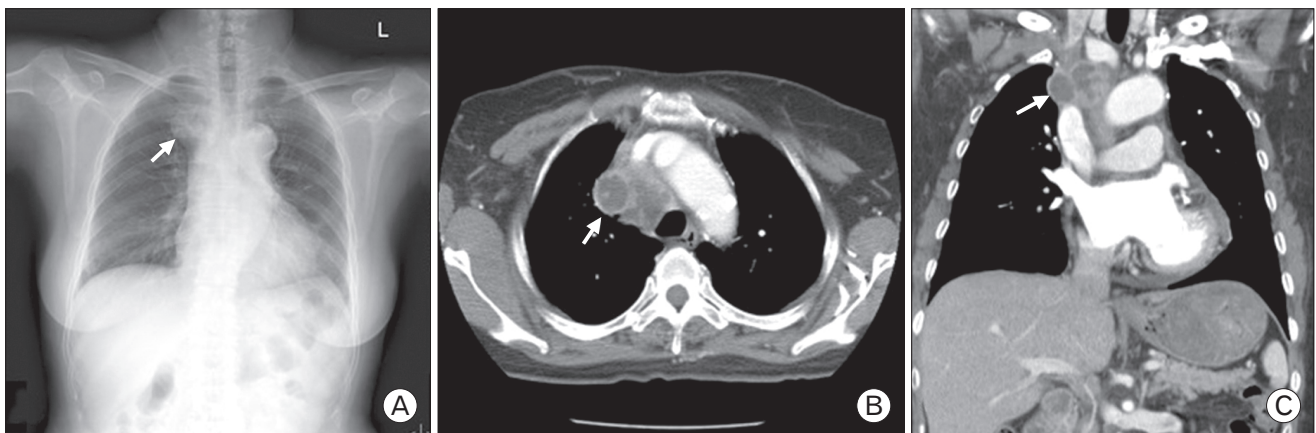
Radiologic findings of the chest. (A) Chest radiograph showed contour bulging (indicated by white arrow) at right mediastinum. (B) Computed tomography showed multiple mediastinal lymph nodes enlargement with central low density and peripheral rim enhancement (indicated by white arrow). (C) Coronal view of computed tomography revealed conglomerate mass encasing and compressing the superior vena cava (indicated by white arrow).
